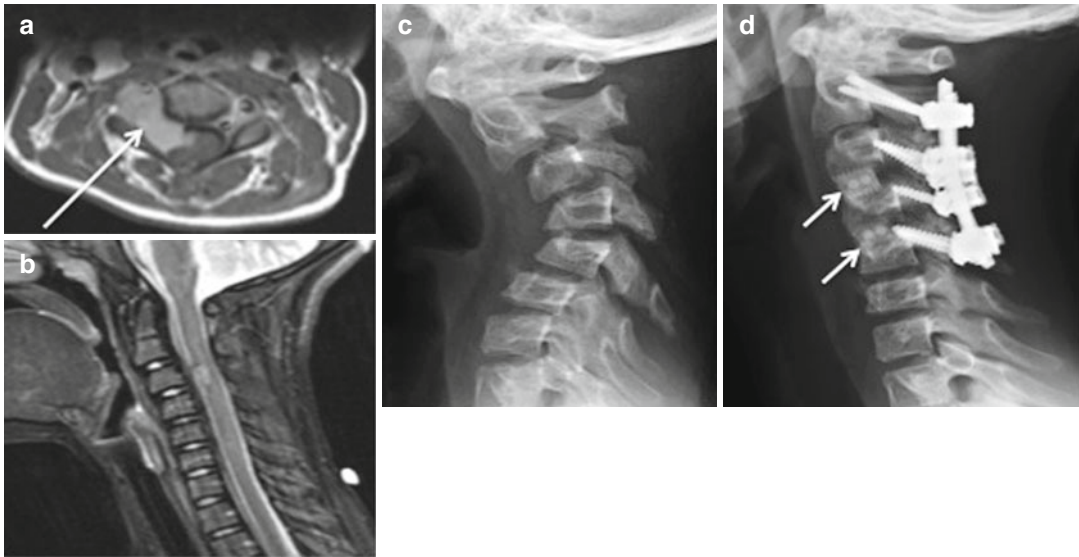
Preoperative. (a) Axial MR image of an 11-year-old girl showing tumor (*arrow*) and (b) sagittal MR image showing the small degree of straightening of cervical lordosis. (c) Lateral radiograph showing
